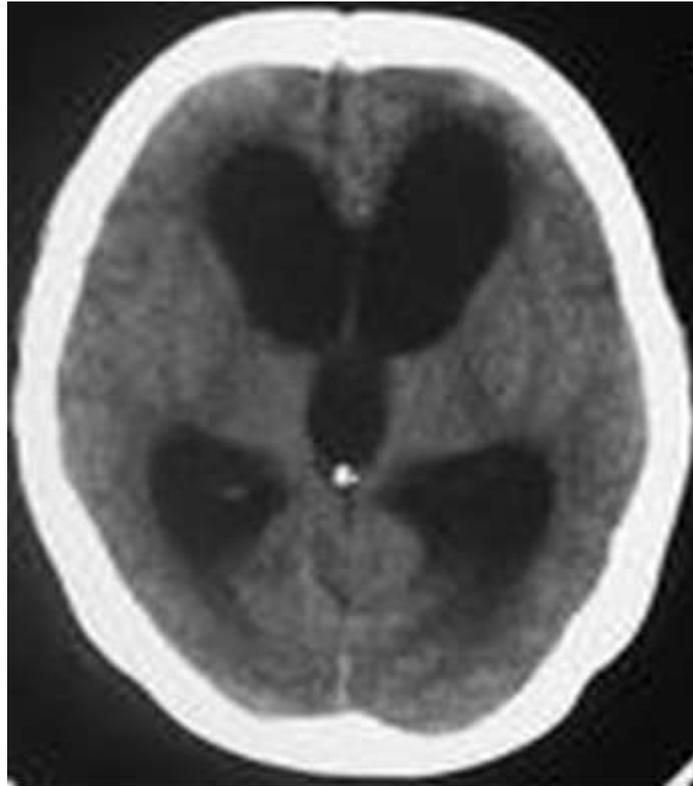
CT scan Brain showing hydrocephalus
